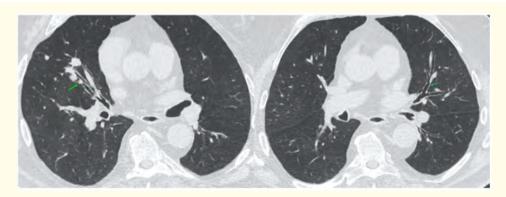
Axial CT showing diffuse bronchial thickening with endobronchial impaction (green arrow).
